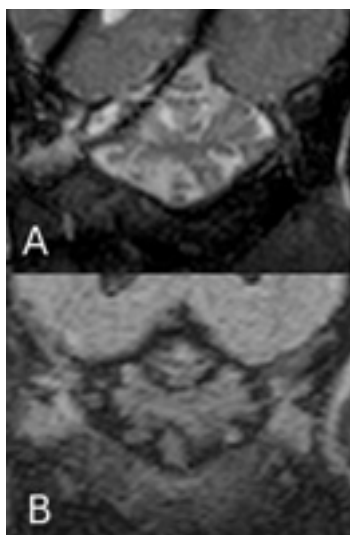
A, Dorsal plane steady state gradient echo (BASG) of the cerebellum. B, Dorsal plane fluid attenuated recovery sequence (FLAIR). In the BASG sequence there is marked widening of the CSF spaces visible. These hyperintense spaces are suppressed in the FLAIR indicating the CSF nature of the fluid within the spaces.
